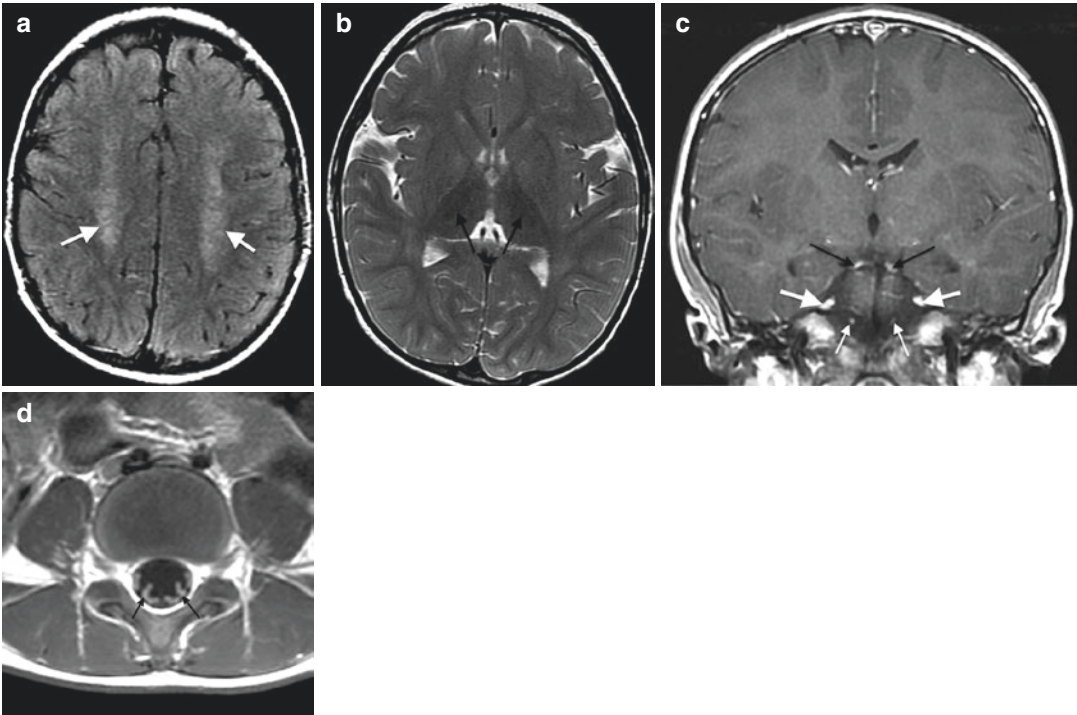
2-year-old male with metachromatic leukodystrophy. Axial T2 FLAIR images (TR/TE/IT ms, 10,002/137/2200) (a) demonstrate hyperintense deep cerebral white matter signal sparing the U-fibers with a subtle striated, “tigroid” appearance (arrows). Axial T2WI (TR/TE ms, 4300/99) (b) shows abnormal hypointense signal in the thalami (arrows). Coronal post-contrast
